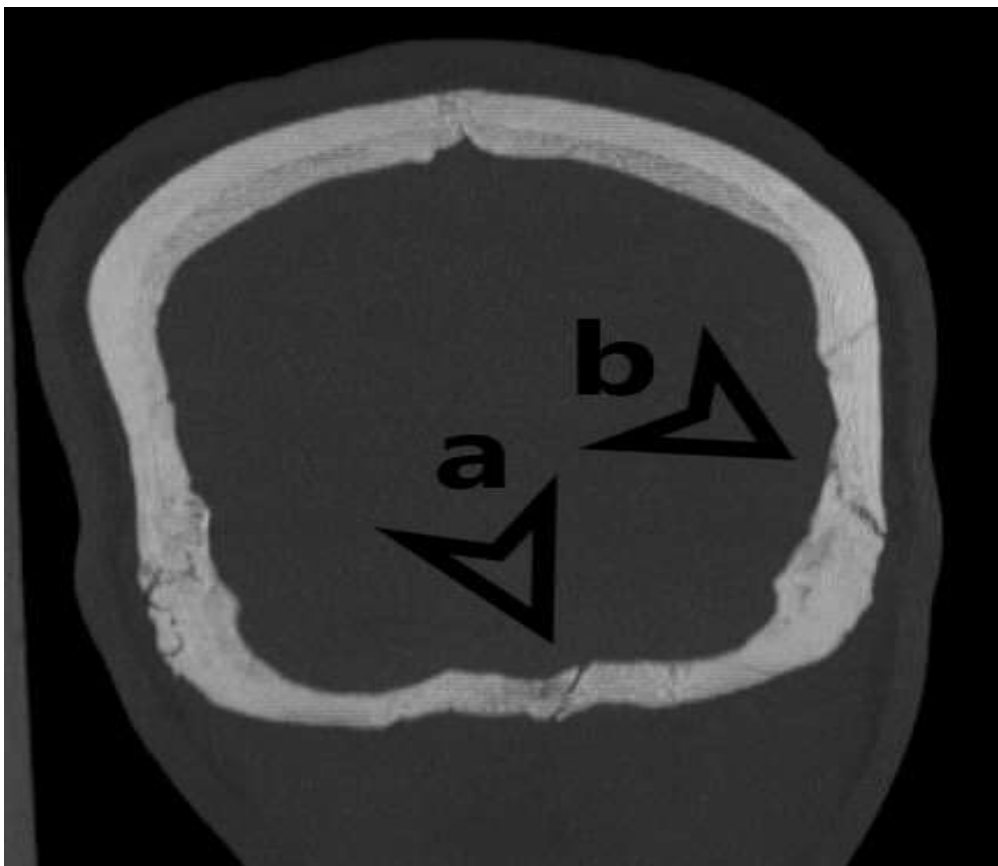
Coronal section of CT scan of skull showing fracture with arrow head 'a' and wormian bone with arrow head 'b'.
